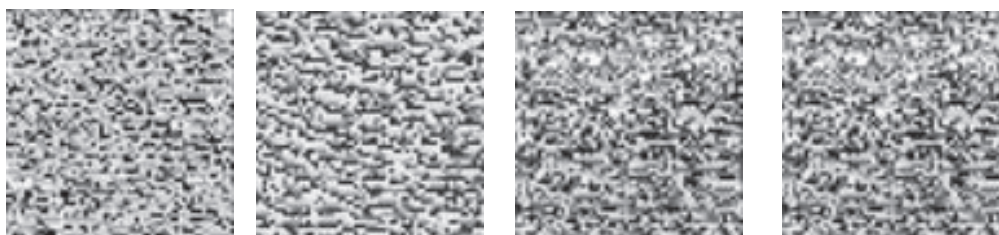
Differences that are imperceptible to the naked eye, but can be detected by the complex analysis of the ultrasonic image in the following cases: healthy liver (a), fatty liver (b), hepatitis (c) or cirrhosis (d) (from left to right).
